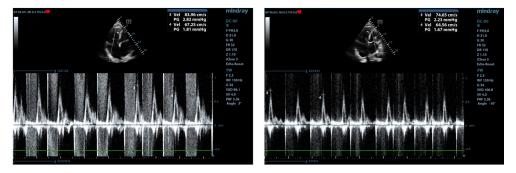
c.4.Transtricuspid (left) and transmitral flow (right) with respiratory variations <25% in a case with restrictive cardiopmyopathy (PW Doppler, 4-chambers view)
